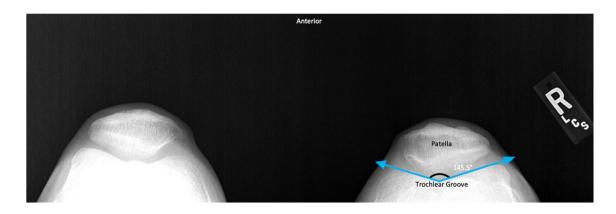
Sulcus Angle. Merchant view radiograph demonstrating an increased sulcus angle greater than 145° consistent with trochlear dysplasia of the right knee
